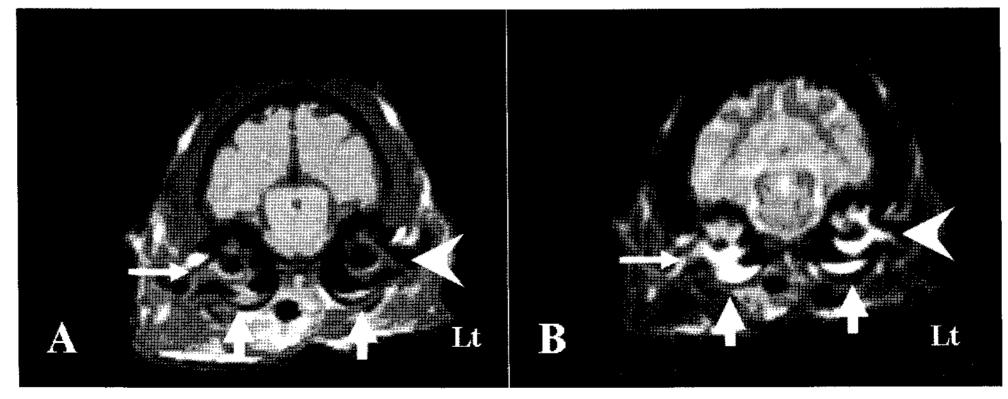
MR images of the present case. Panels A and B shows transverse T1- and T2-weighted MR images at the level of the tympanic bulla, respectively. The tympanic bullas on both sides are filled by exudates and inflammated (big arrows). The right side tympanic bulla show more severe changes then those of left side. Small arrow indicates the cotton tip in right ear canal and arrowhead show inflamed left ear canal.
